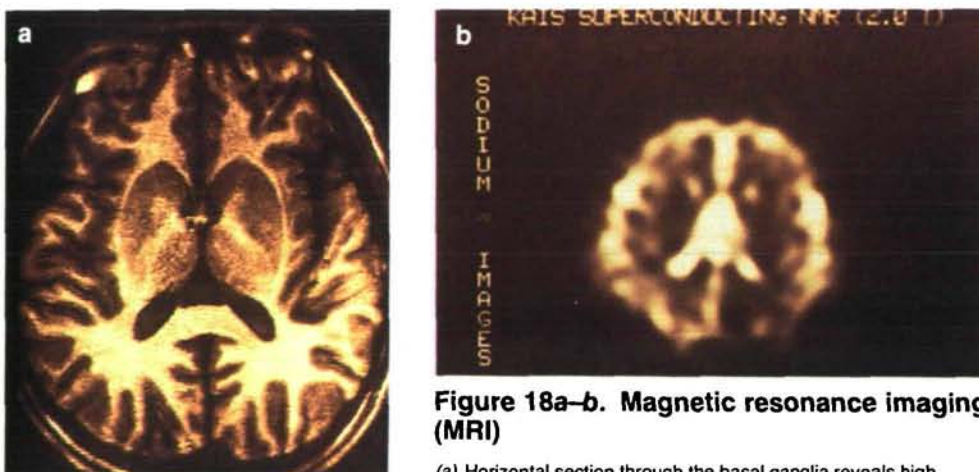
Magnetic resonance imaging (MRI)
